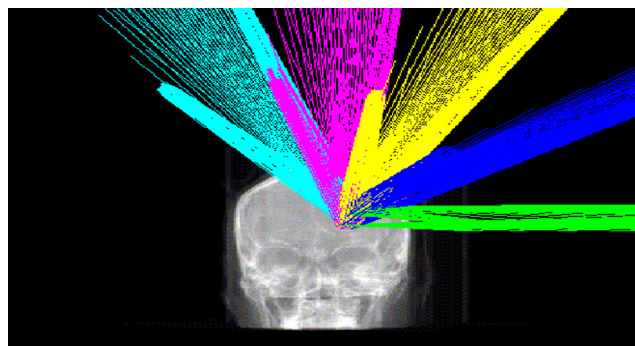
Digitally reconstructed radiograph showing the configuration of multiple non-coplanar beams utilized for treatment with volumetric-modulated arc therapy.
